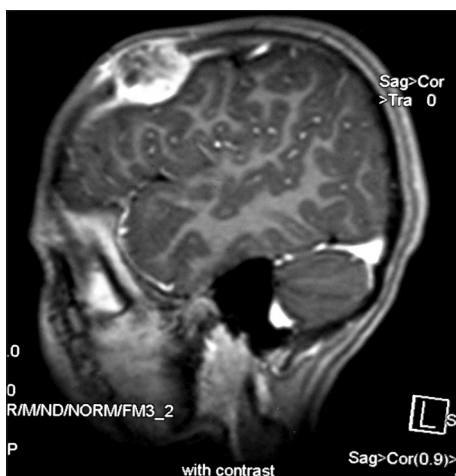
Magnetic resonance imaging showing an enhancing mass with a wide dural attachment and a lytic lesion in the overlying skull
